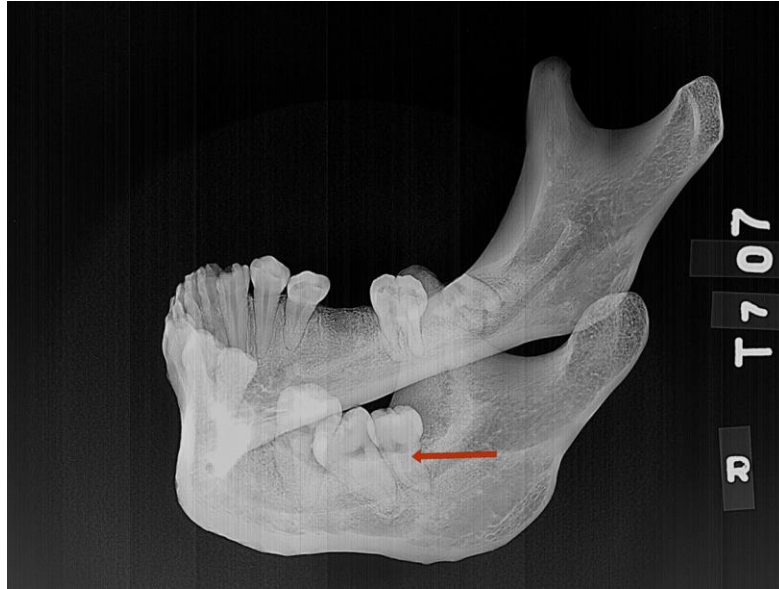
Oblique X-ray image of the mandible shows that the distomolar has only one root and that there is no antimeric distomolar. Note the large extent of the pulp cavity in the distomolar, suggesting it is a taurodont molar.
